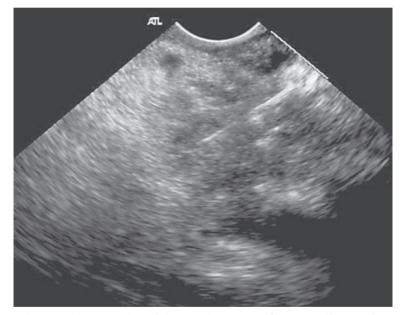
Endoscopic ultrasonography with fine-needle aspiration of a suspected lesion in the pancreatic head of a patient with a negative helical multidetector CT scan
